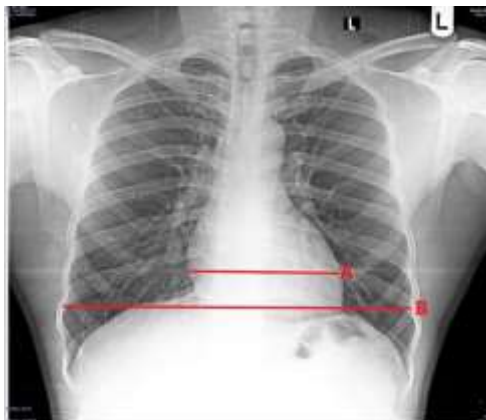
Posteroanterior chest radiograph showing the measurement of the transverse cardiac diameter (A) and transverse thoracic diameter (B).
